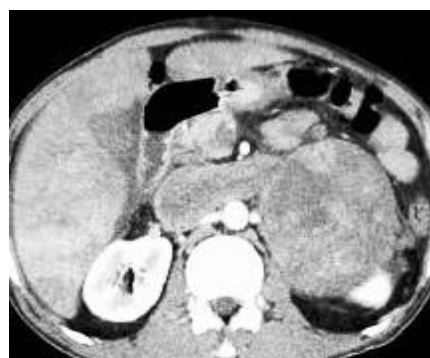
CT scan revealed heterogeneous enhancing mass lesion with central necrosis in left adrenal region pushing the left kidney downwards
